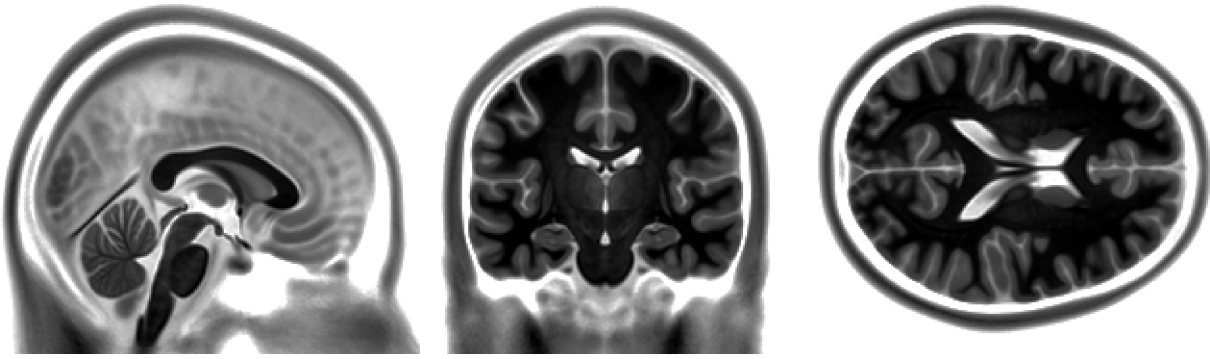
Sagittal, coronal and axial section of the MNI ICBM 152 template (MRI)
